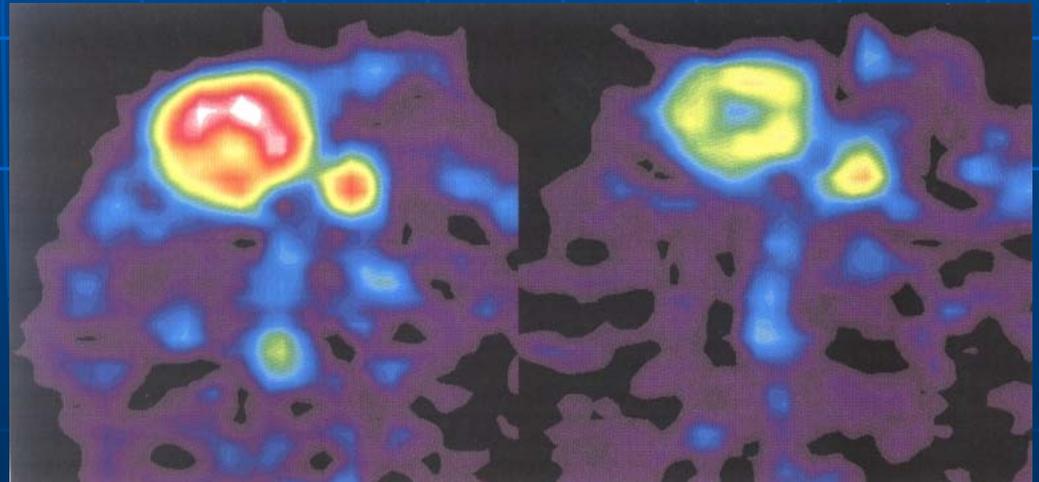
SUV images showing carcinoid liver metastases in the ventral part of the right liver lobe before and 3 months after start of medical therapy. The decrease in HTP tumour accumulation is evident.
